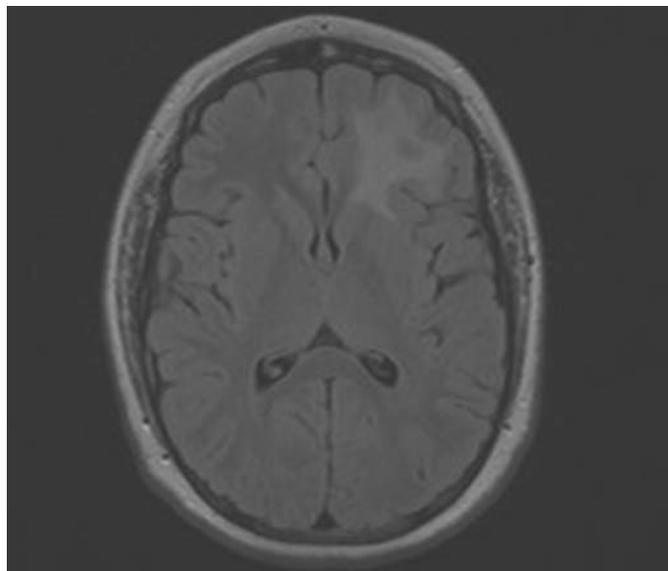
MR image of the head showing re-occurrence of extensive periventricular and subcortical white matter T2 signal abnormality within the inferior left frontal lobe.
